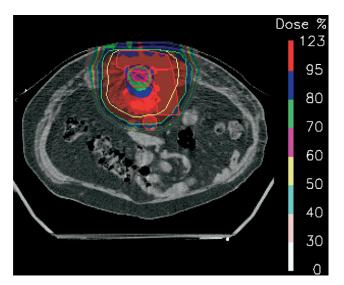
Midplane dose distribution of a case irradiated postoperatively for lumbar chordoma. Prescribed dose (100%) corresponds to 45.5 CGE which was delivered in fractions of 2.0 CGE (conventional proton therapy) and 2.5 CGE (intensity-modulated proton therapy) with selective sparing of the cauda equina. Dose per fraction to the cauda never was higher than 2.1 CGE. The remainder of the treatment was delivered with radiotherapy for reasons detailed in the text. The green line outlines the planning target volume, and the yellow line the clinical target volume. Red lines mark anatomic structures, technical volumes, and a volume drawn manually to compensate for artifacts in the planning computed tomography.
